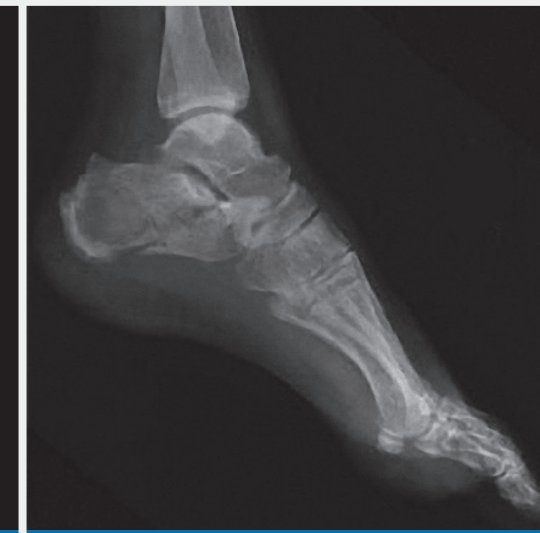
Foot radiograph of the non-union.
